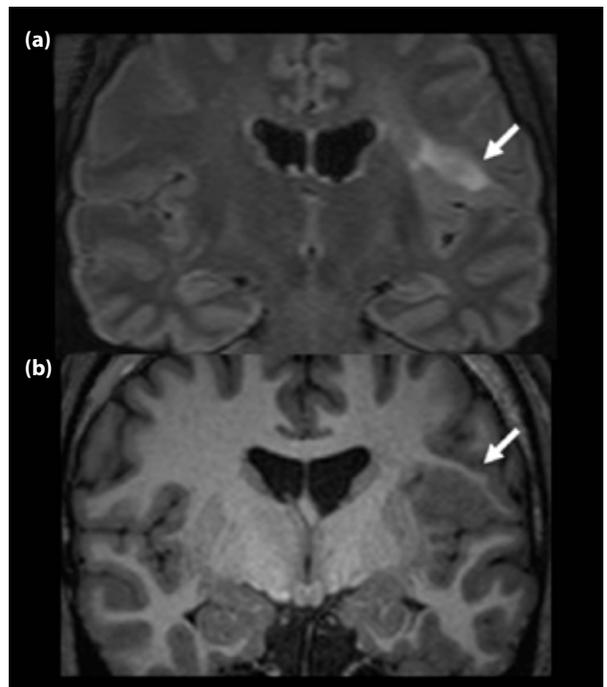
FLAIR (a) and T1 (b) MRI coronal slices showing left fronto-insular FCD with transmantle sign (arrow).
